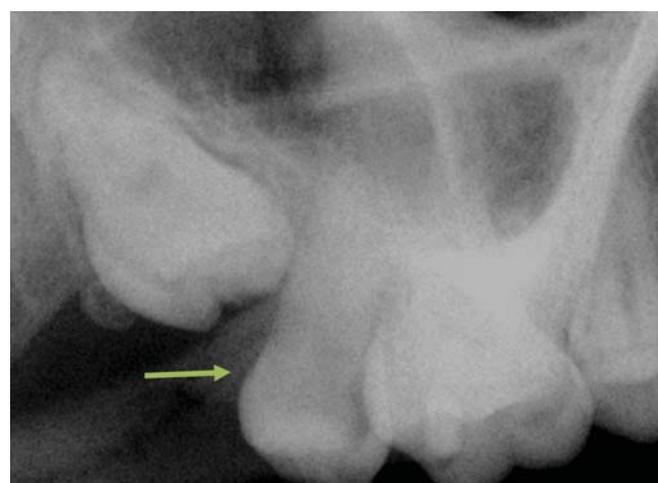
Periapical radiograph
